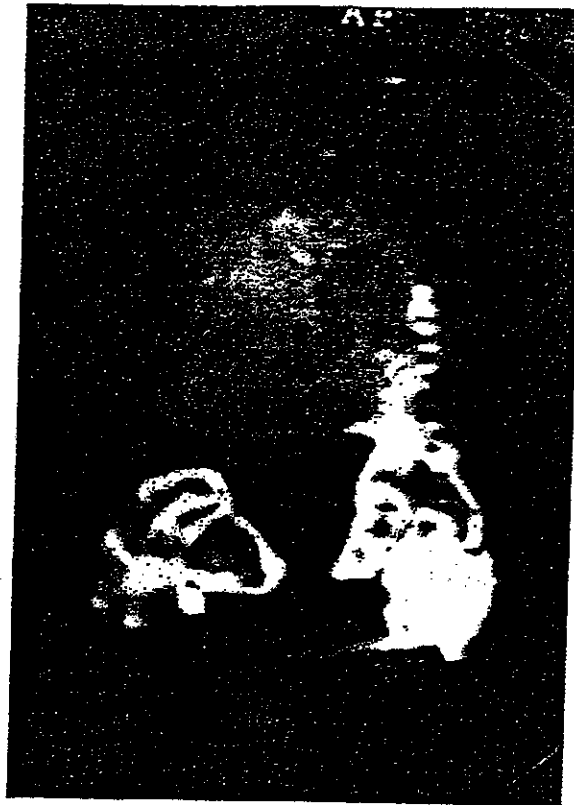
Fusion of the articular graft: X-ray features.
